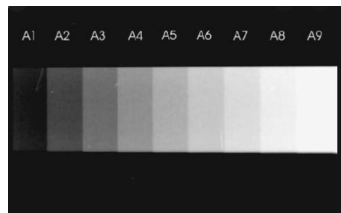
X-ray image of step block
